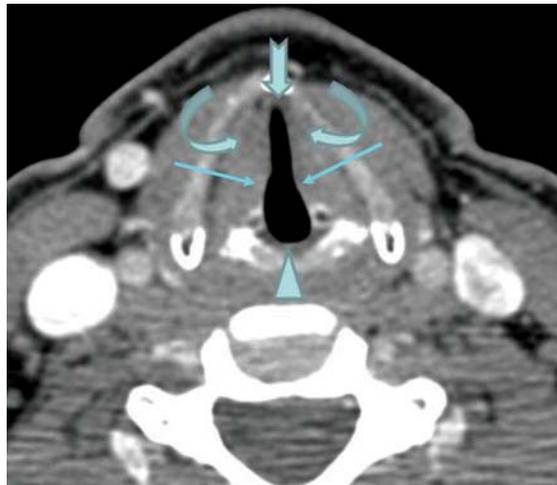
Axial CT scan through the glottis showing the true vocal cords (arrows), anterior (notched arrow) and posterior commissures (arrowhead). The paraglottic space (curved arrows), at this level, has soft tissue density due to the presence of thyroarytenoid muscle. There is no submucosal tissue at the commissures
